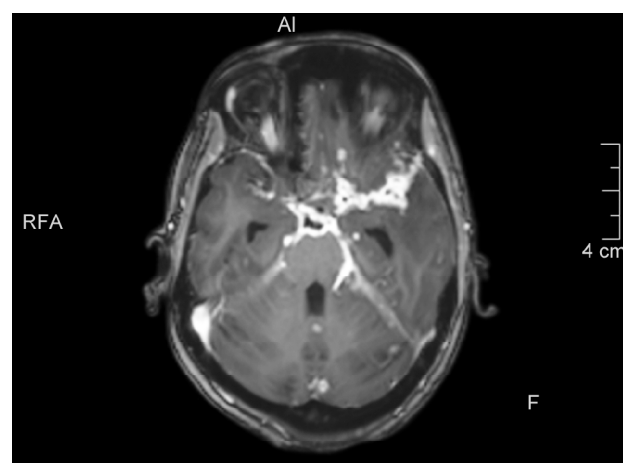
Contrast-enhanced MRI T1W axial image showing thick exudates at the perimesencephalic cistern, suprasellar cistern and left sylvian fissure
